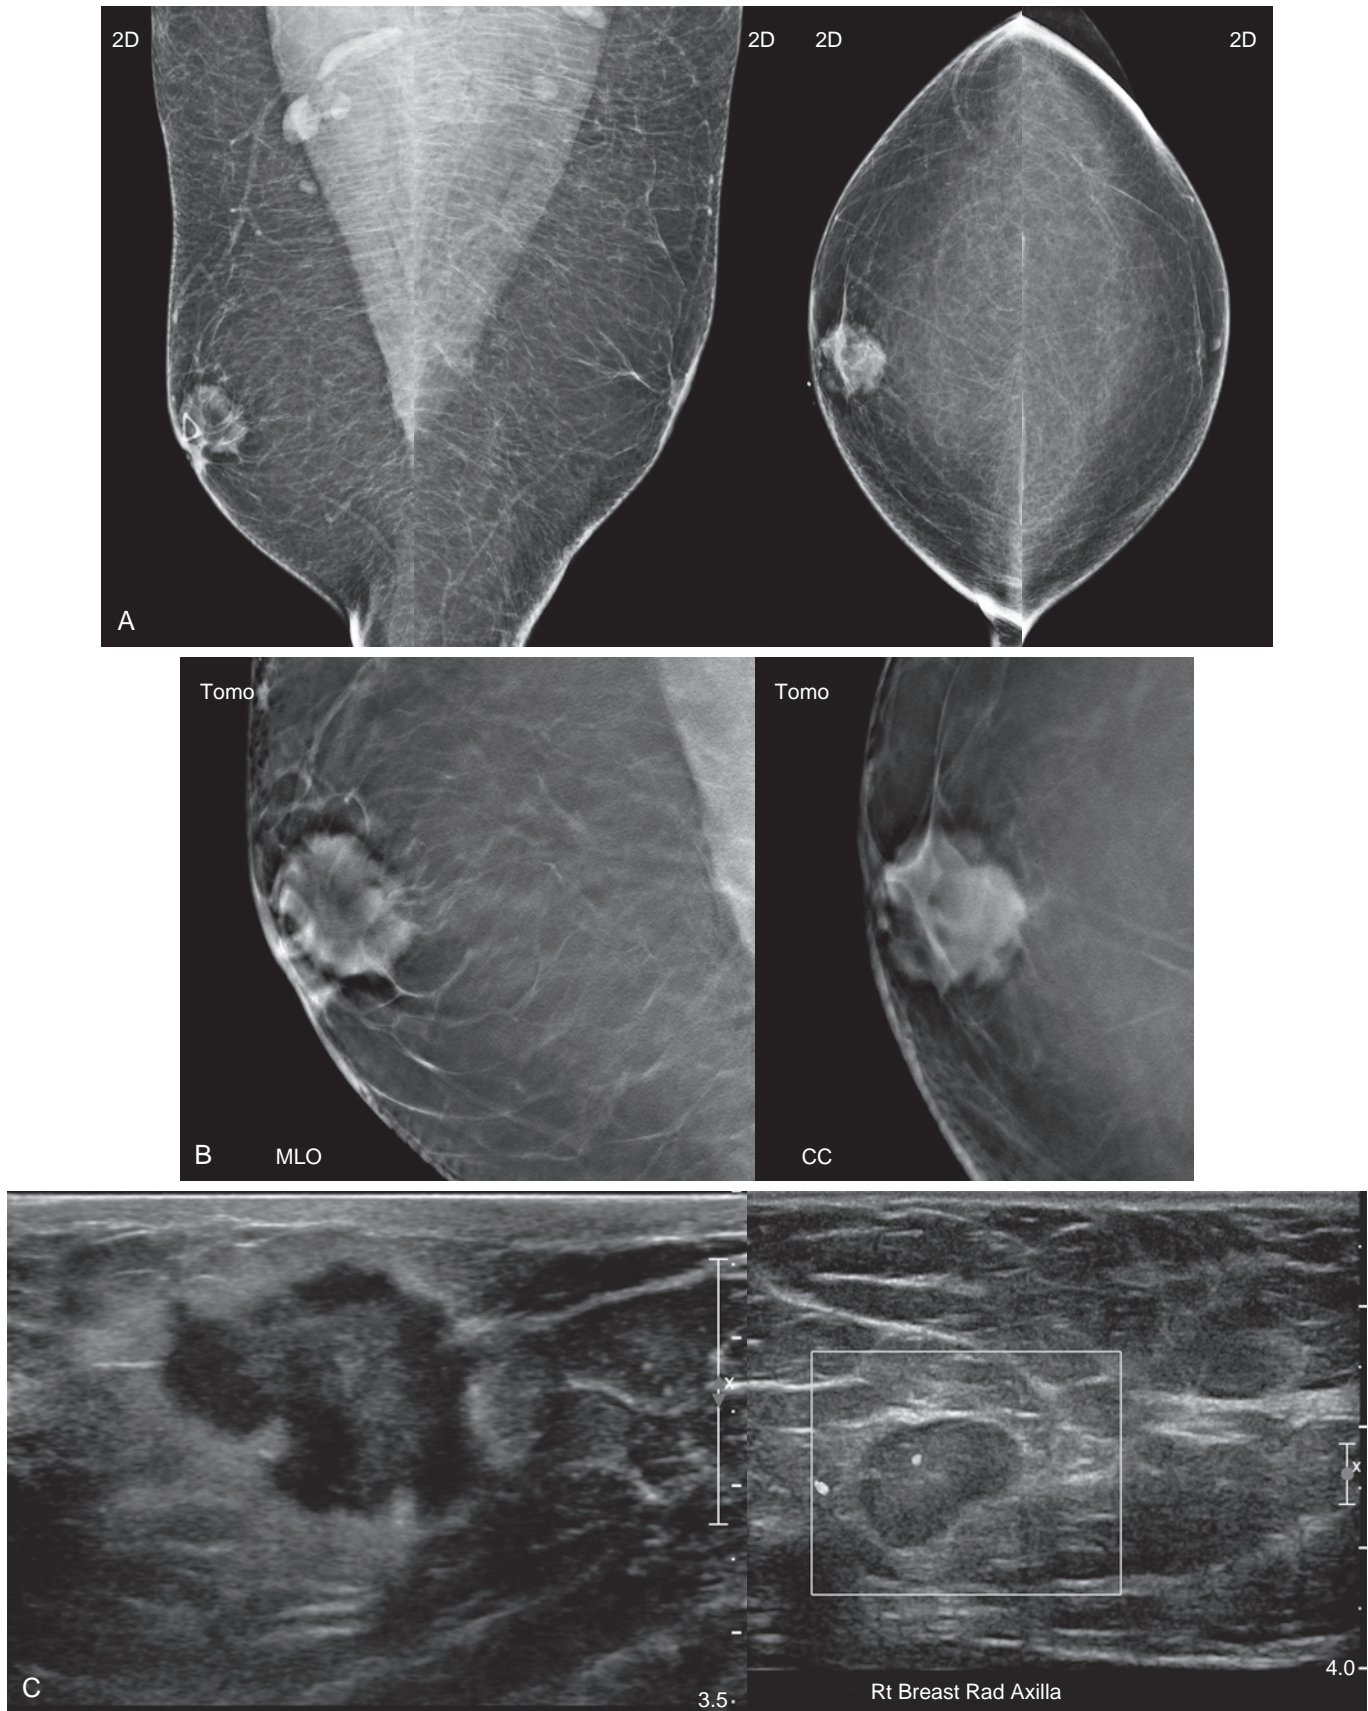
Breast cancer in a young man. A 42-year-old man with neurofibromatosis presents with a palpable lump near the nipple in the right breast. (A) 2D mammogram reveals an irregular mass with indistinct margins and a prominent axillary lymph node. (B) Tomosynthesis MLO and CC slice views demonstrate the fine spiculations of the margins. (C) Ultrasound shows the markedly irregular mass and enlarged axillary lymph node. Core needle biopsy pathology showed invasive ductal carcinoma, ER/PR/AR+, Her2– with 2/8 nodes positive. Women with neurofibromatosis have a fourfold risk of breast cancer. No statistics are available on the risk for men with the syndrome.
